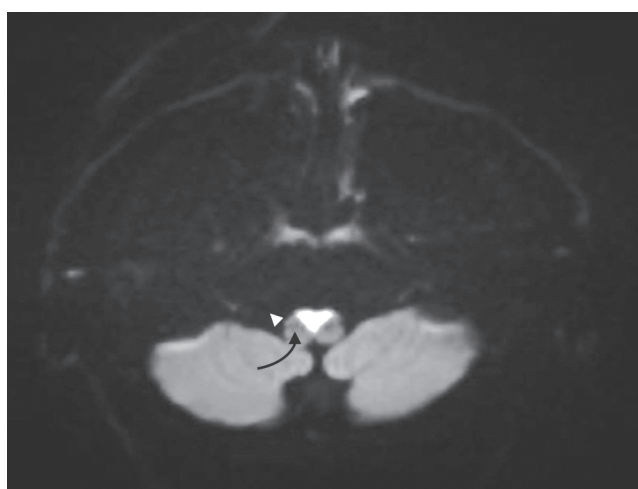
Axial diffusion-weighted MRI of the brain showing heart-shaped diffusion restriction in the ventral medulla (heart sign)
